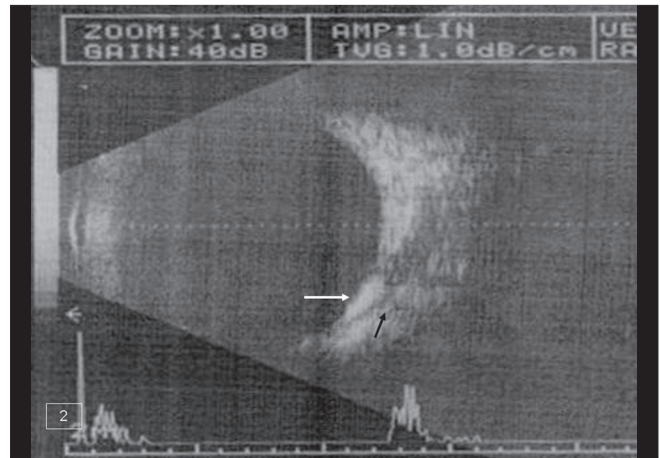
Ultrasound B-scan showing hyperreflective mass lesion in the posterior pole (white arrow) with aftershadowing of orbital soft tissue posterior to it (black arrow) suggestive of choroidal osteoma
